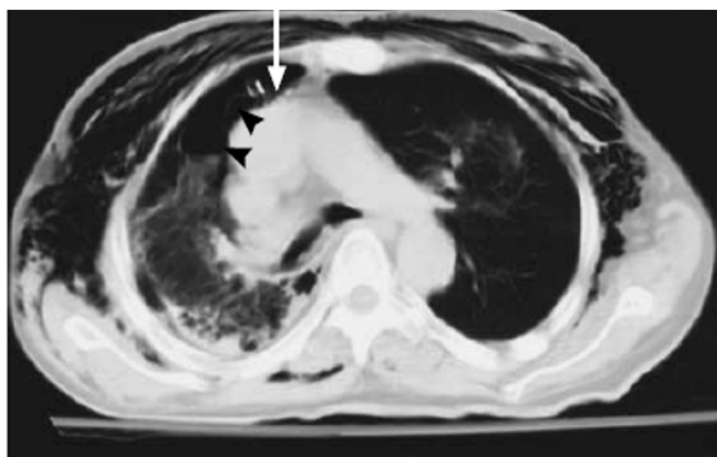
Pneumothorax as seen in CT scan, the black arrow indicates the presence of multiple bullae [13].
